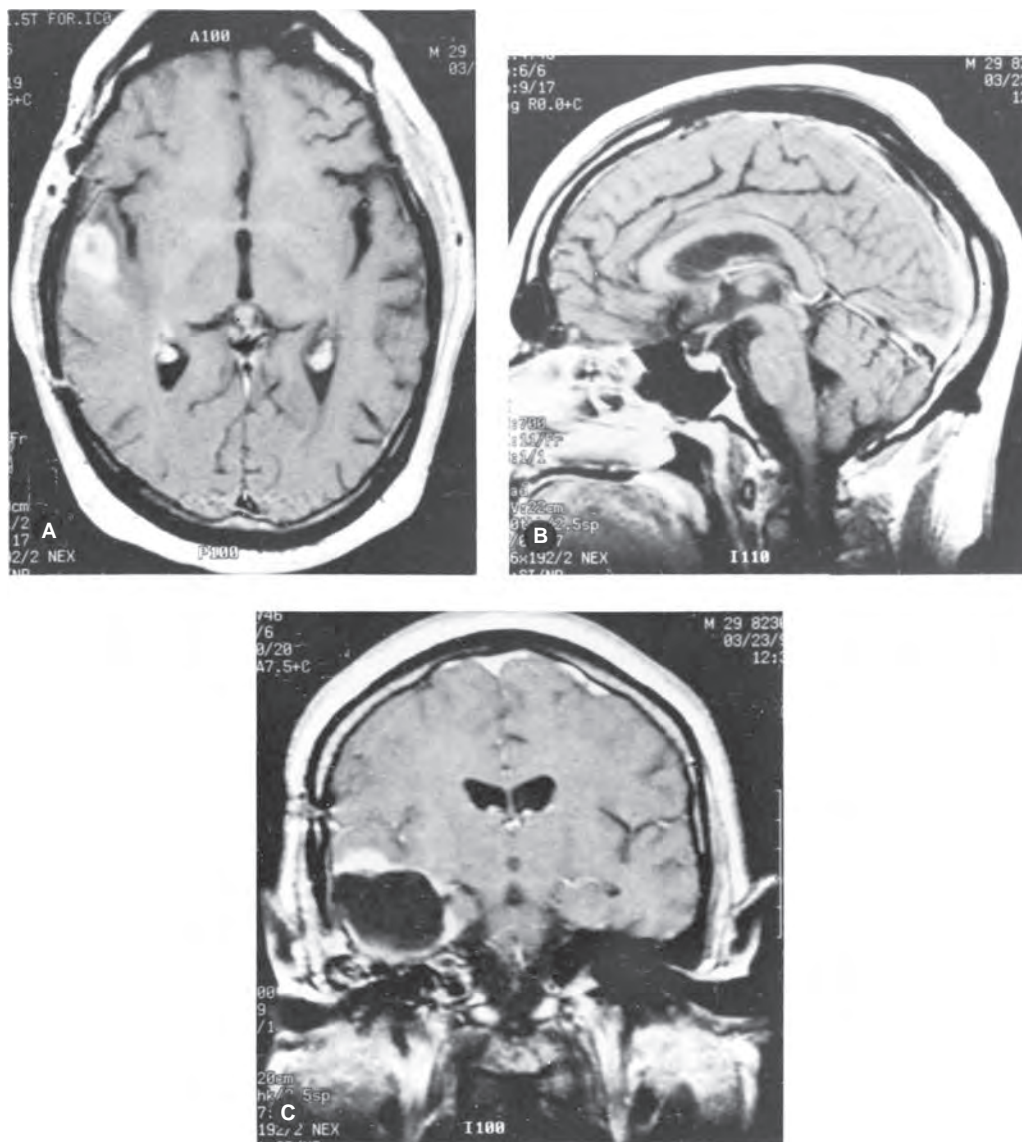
Examples of magnetic resonance images of the head. A: Transverse plane. B: Sagittal plane. C: Coronal plane.
